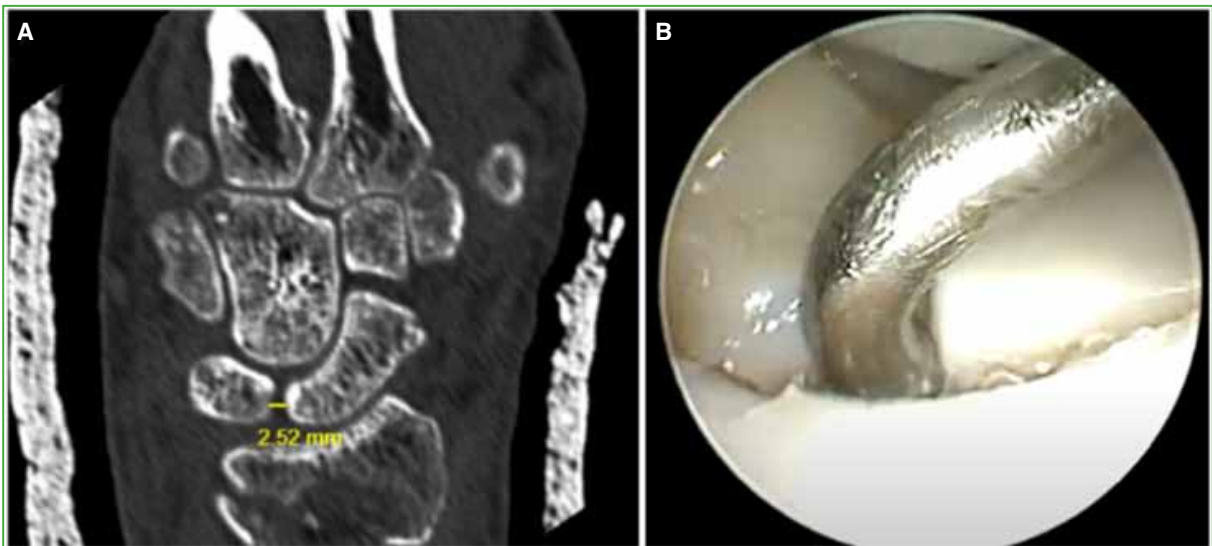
Scapholunate ligament injury. A. Computed tomography of the wrist, coronal section. Scapholunate distance > 2 mm. B. Arthroscopy. Introduction of the probe through the scapholunate ligament observing the scapholunate ligament injury.
